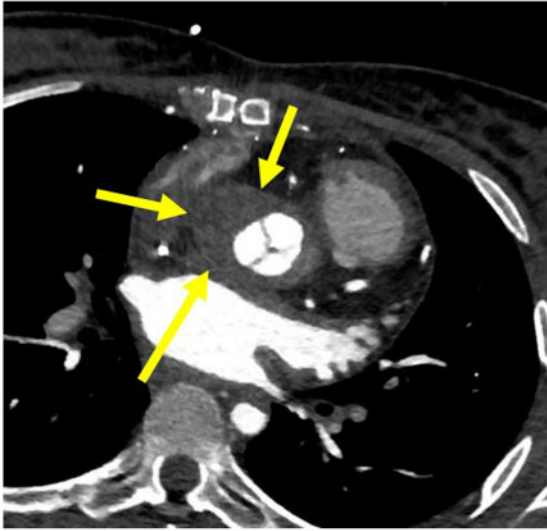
Computed tomography angiography showing a collection around the aortic root consistent with a periaortic abscess.
